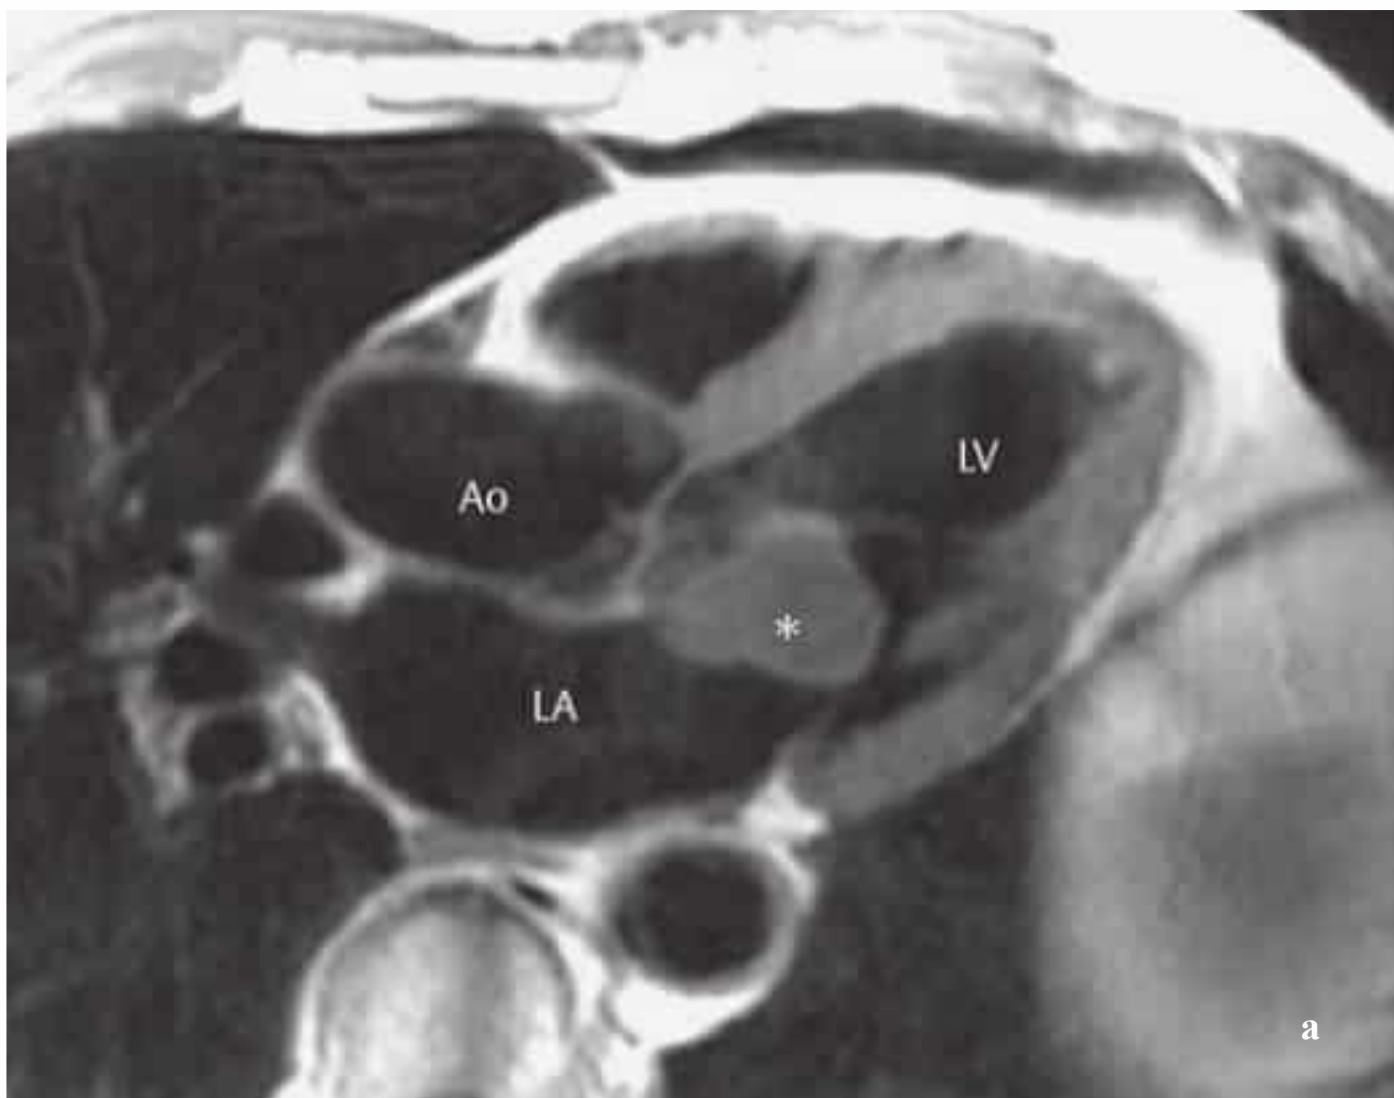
a–c Myxoma (asterisk) that prolapses into the left ventricle in diastole. T1-weighted image (a), T2-weighted image (b), and fat-suppressed T1-weighted image after intravenous contrast injection (c).
